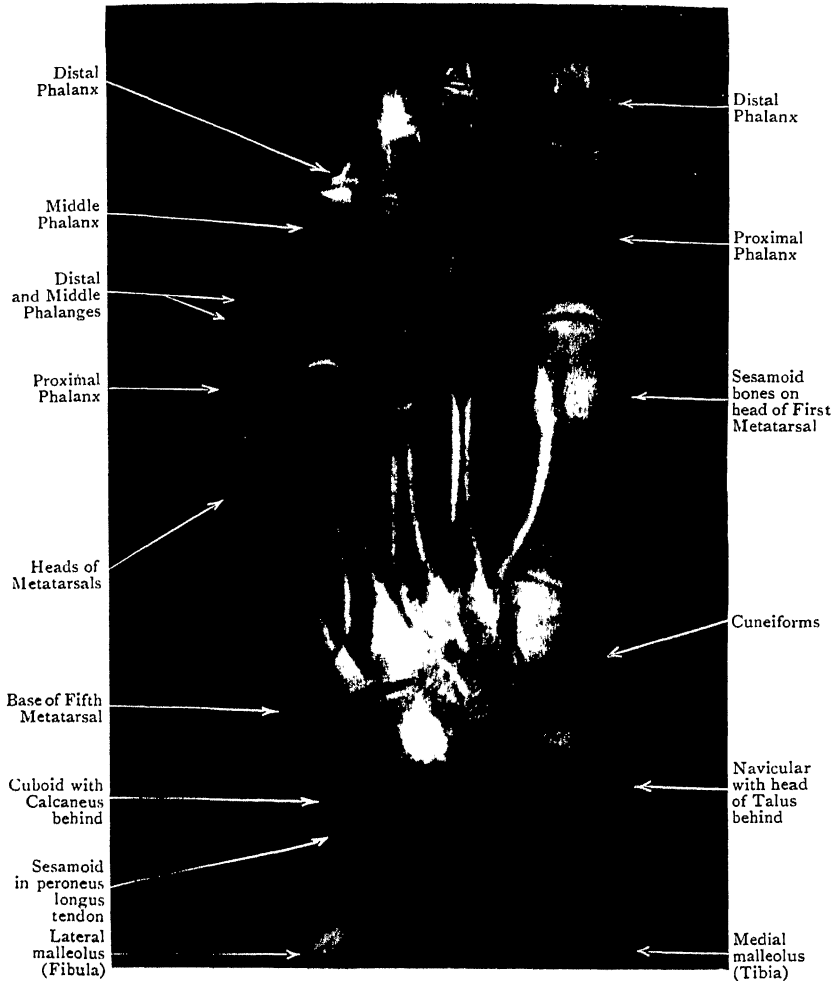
Radiograph of Foot of man aged 48. The foot was plantar-flexed, with the sole against the film-container.
